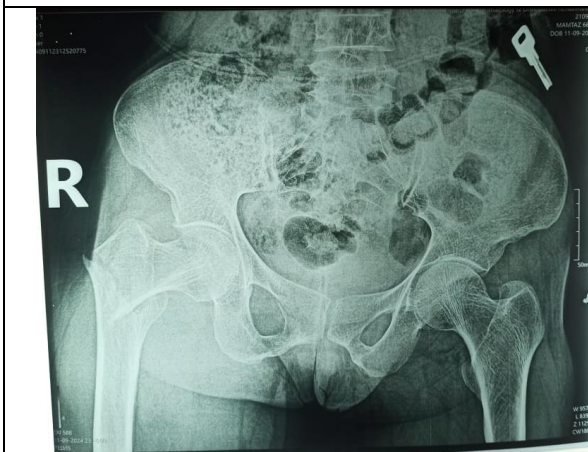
Pre-operative X-ray by PFN
